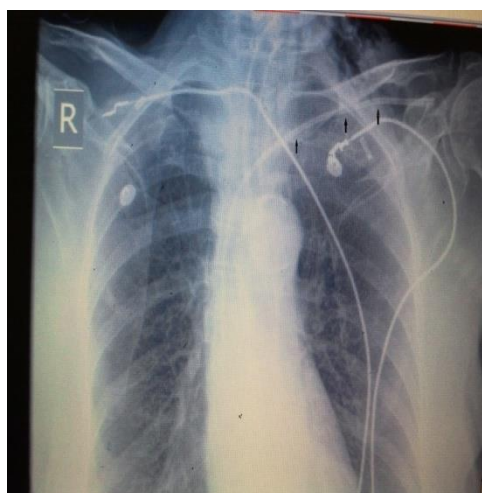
Chest X-ray on the right shows CVC that we later on put through left subclavian vein (path highlighted by black arrows); tracheostomy tube can also be seen.
